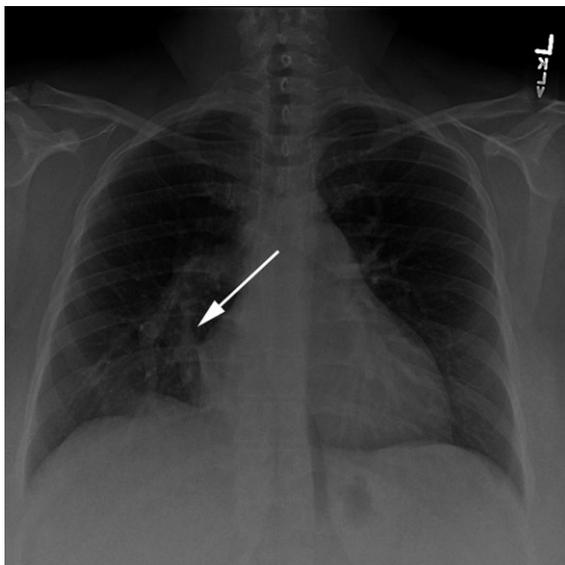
PA chest x-ray demonstrates a prominent size cardiac silhouette with a typical scimitar vein noted within the right lung field (arrow).
